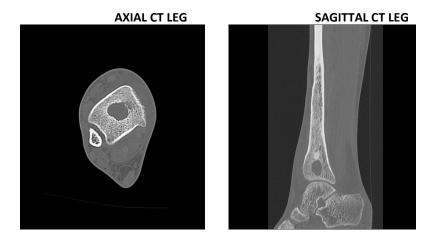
shows the axial and sag sections of plain CT done for lower end of tibia with ankle joint which shows a well defined homogenous lytic lesion in the lower end of tibia which appears isodense to the muscle plane and sclerotic margins.
